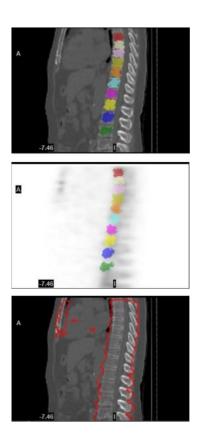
SPECT/CT images
